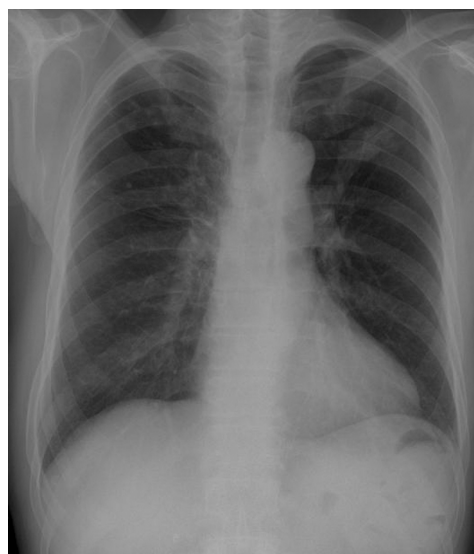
Preoperative chest radiograph shows calcified granulomas in both upper lobes, and a mass lesion in the left upper lobe.
